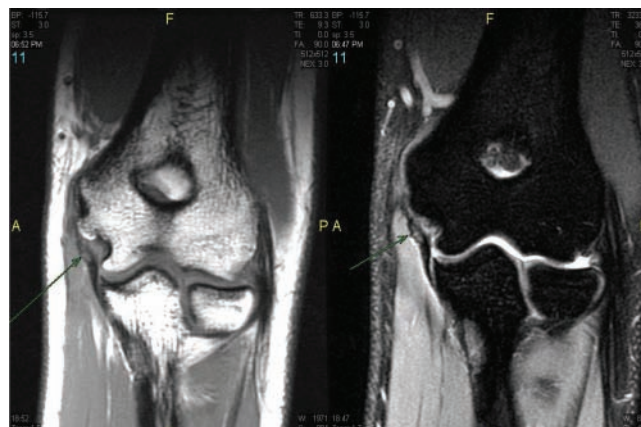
Magnetic resonance imaging scans of proximal partial ulnar collateral ligament tears (arrows).
